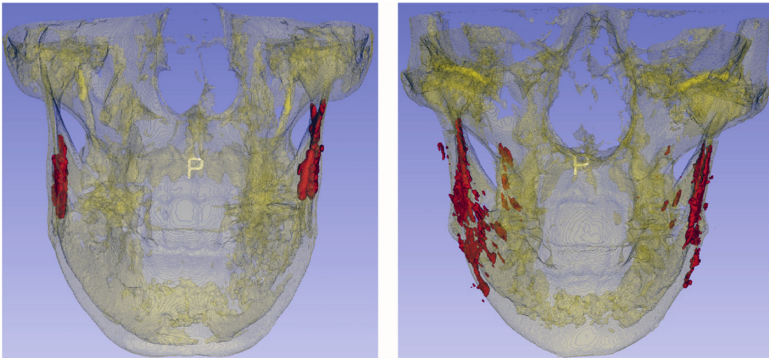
3D Surface model registration: 3D ultrasound reconstruction (red) and CBCT (yellow) surface models show that ultrasound is able to accurately capture the outer layer of bone in the mandibular ramus (Color figure online).
